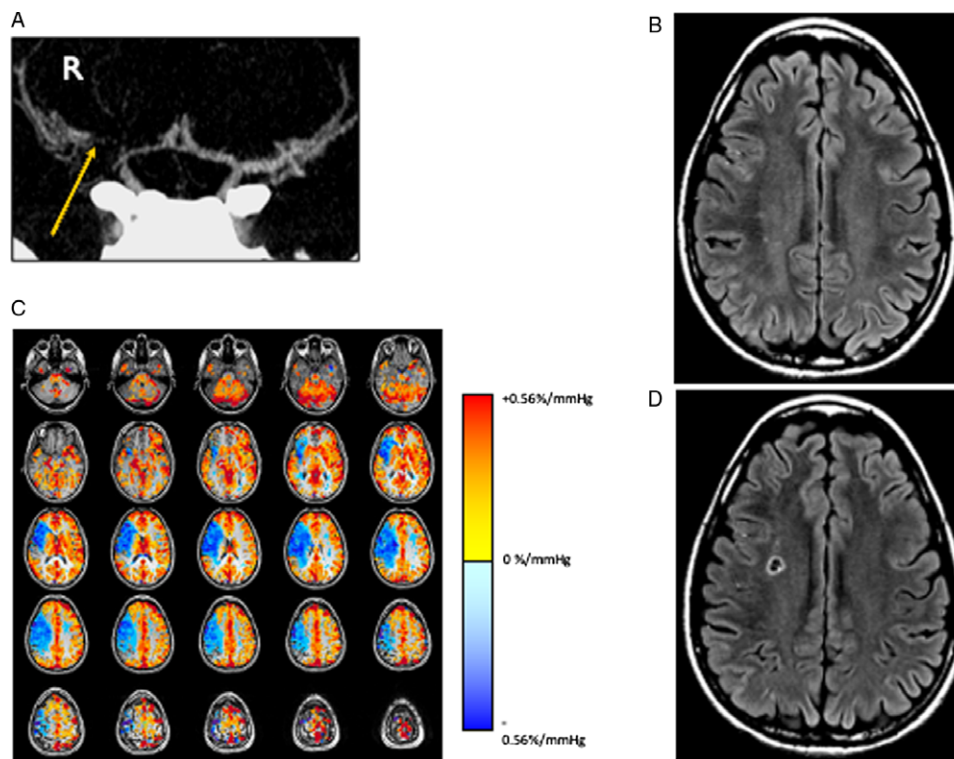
Example of a patient who presented with transient left face and upper and lower extremity paresthesia and weakness. (A) CT angiogram shows severe narrowing of the right middle cerebral artery (yellow arrow). (B) T2-weighted FLAIR image showed no evidence of brain infarct. (C) CVR study shows reduced (paradoxical) reactivity throughout the right MCA territory and preserved reactivity elsewhere. (D) 4-month follow-up MRI demonstrating a new infarct in the right MCA territory corresponding to the region of impaired CVR.
